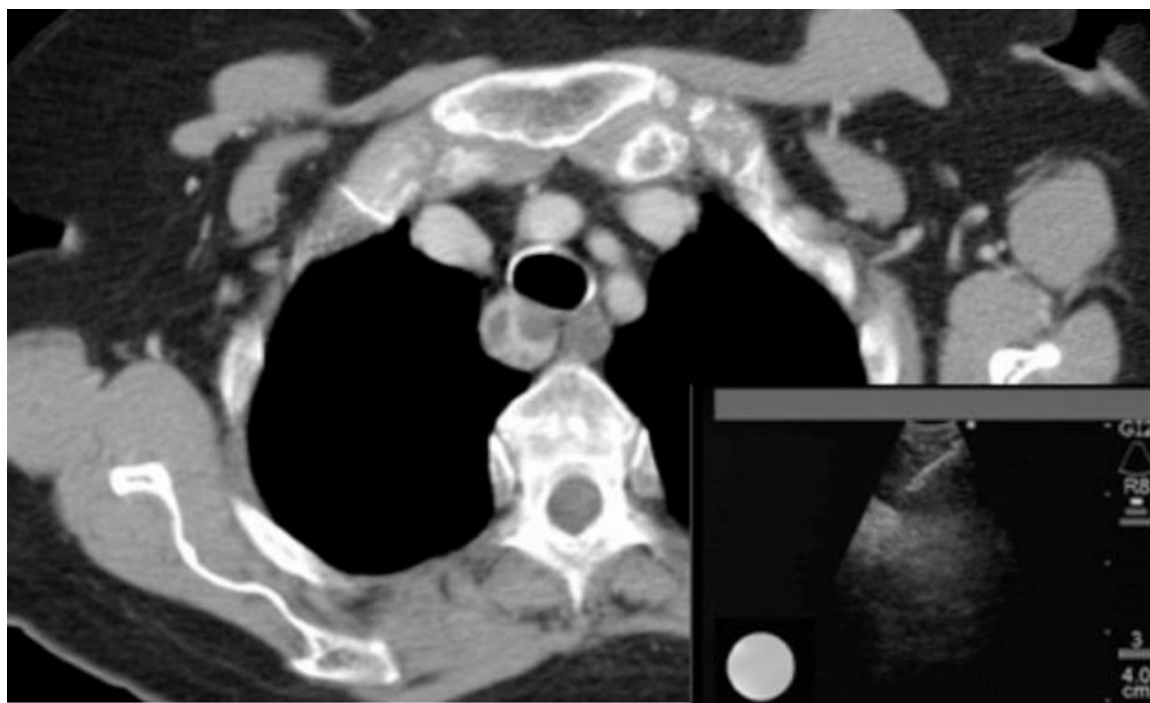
CT image and endobronchial ultrasonography with transbronchial needle aspiration. Reproduced with permission from the American College of Chest Physicians¹⁶.
